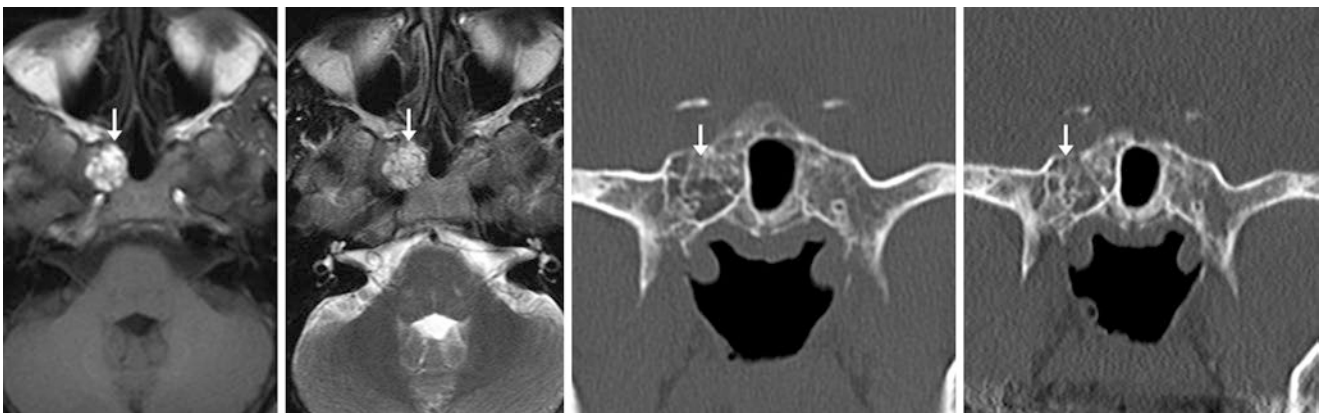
A 43 year old in whom fat signal intensity (*arrows*) was noted within the right side of the sphenoid on non-fat-suppressed 1.5T MRI axial T1WI (*left*) and T2WI (*left middle*) in 2004. Coronal CT at that time (*right middle*) confirmed arrested pneumatization, which was unchanged in the year 2011 (*right*)
